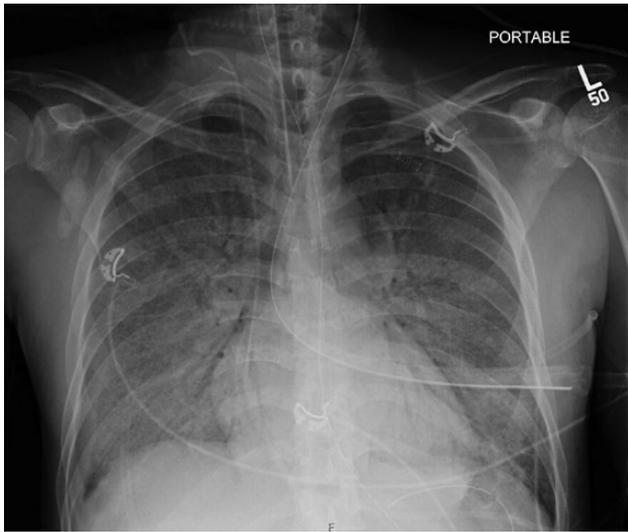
Chest X-ray on transfer to our facility, showing diffuse hazy opacities.
